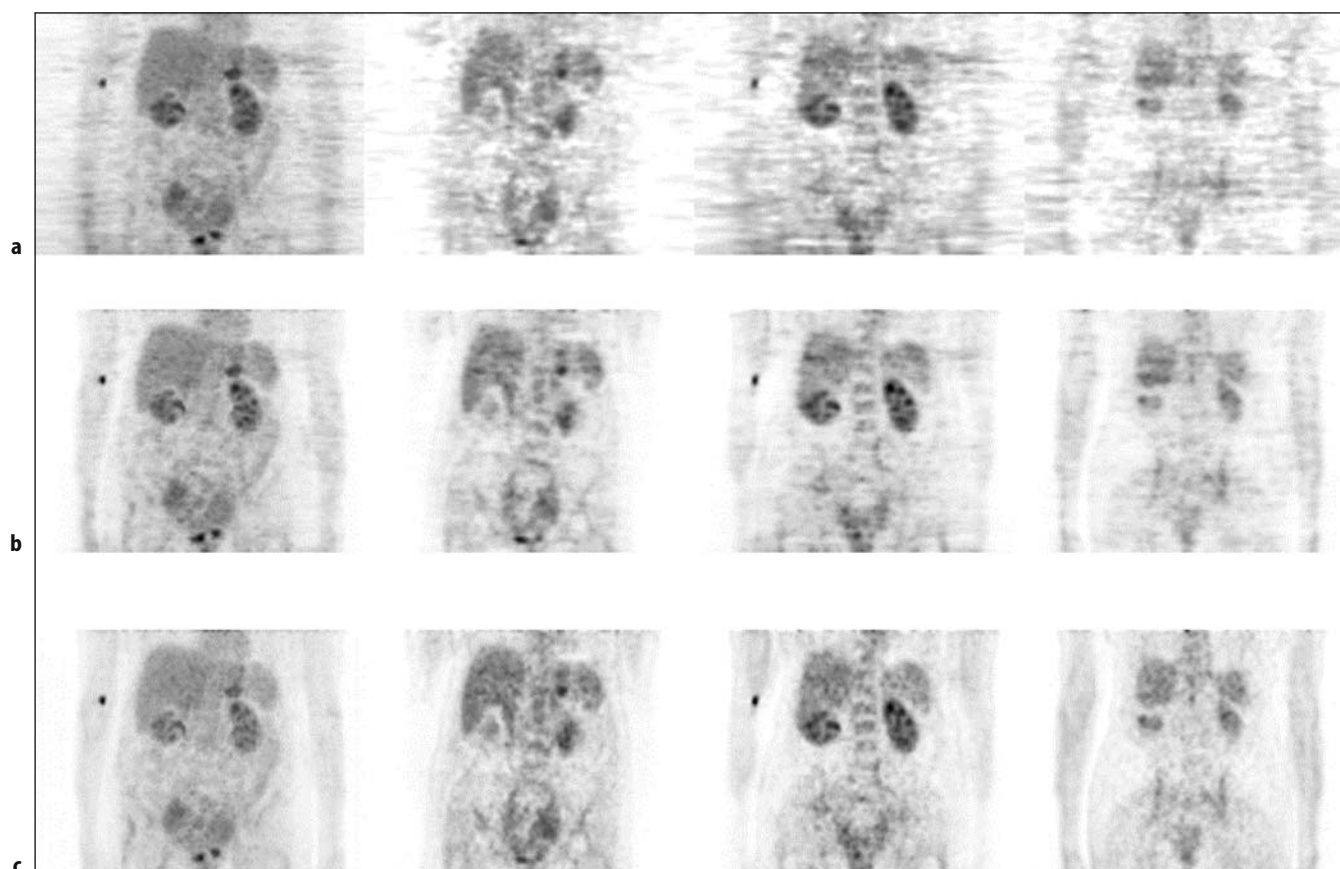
Comparison of image reconstruction methods. Substantial improvements in whole-body FDG PET image quality have occurred due to refinements in image reconstruction algorithms. Shown above are anterior projection images and coronal image sections of the abdomen and pelvis, with acquisition beginning about one hour after FDG administration. Two-dimensional acquisition was used (six minutes per bed position) and transmission scanning was performed with rotating Ge-68 rod sources (four minutes per bed position). The same emission and transmission data are shown after reconstruction by filtered back-projection (a), by statistical or iterative reconstruction using ordered subset expectation maximization (OSEM) (b), and by attenuation-weighted statistical reconstruction (c). [Courtesy of Technical University of Munich and CPS Innovations Inc., Knoxville, Tennessee.]
